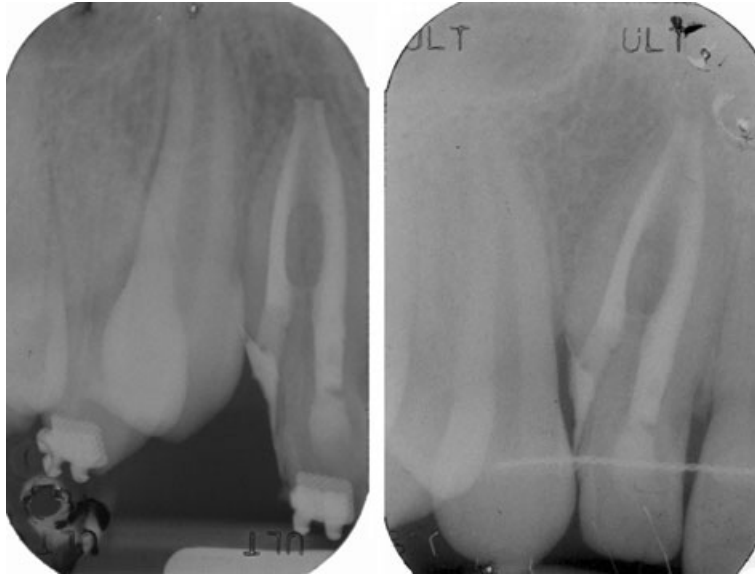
Left: immediate postoperative periapical radiography. Right: periapical radiograph at 6-year follow-up.
